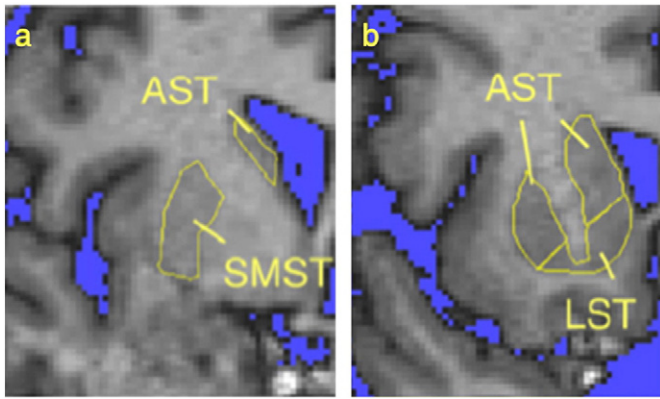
Coronal MRI sections depicting manually drawn ROIs for striatum in one subject; posterior (a) and anterior (b) to the anterior commissure. Right hemisphere is shown. LST = limbic striatum; AST = associative striatum; SMST = sensorimotor striatum (adapted from Cervenka et al., 2008 with permission, Copyright Elsevier Science 2008).
